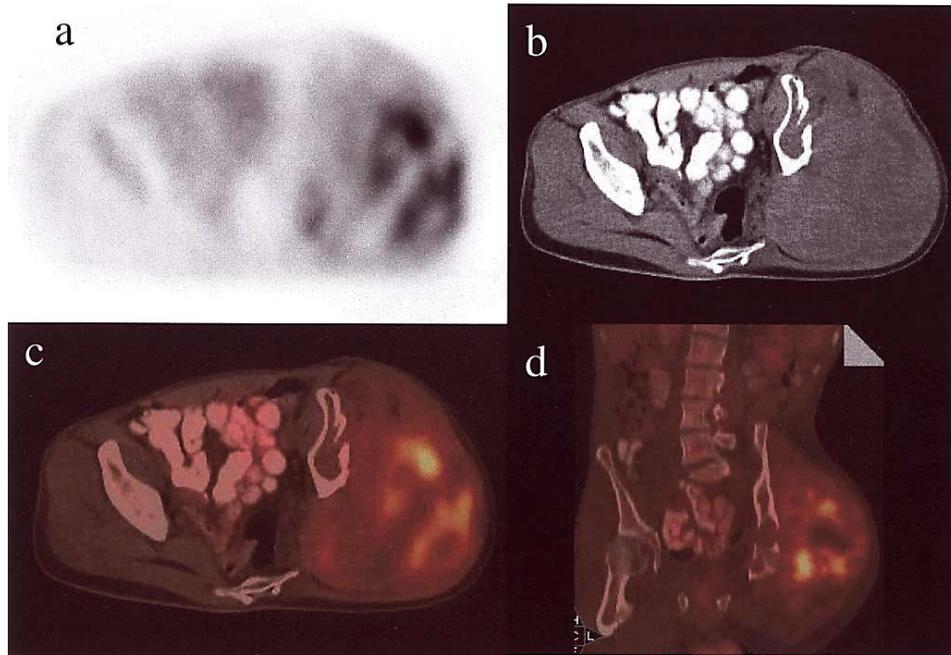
A 28-year-old male patient with a history of neurofibromatosis developed sarcomatous transformation in a left gluteus mass. a: FDG-PET image, b: CT image, c: fused PET/CT image, d: coronal view of PET/CT image. There is a large nearly circular focus of increased FDG uptake in the left gluteus musculature. The mass has a photopenic center. SUV_{max} of this mass is 6.6. There is CT evidence of invasion of the left iliac wing, left acetabulum, and left superior pubic ramus with no increased FDG uptake in these areas on the PET image.
